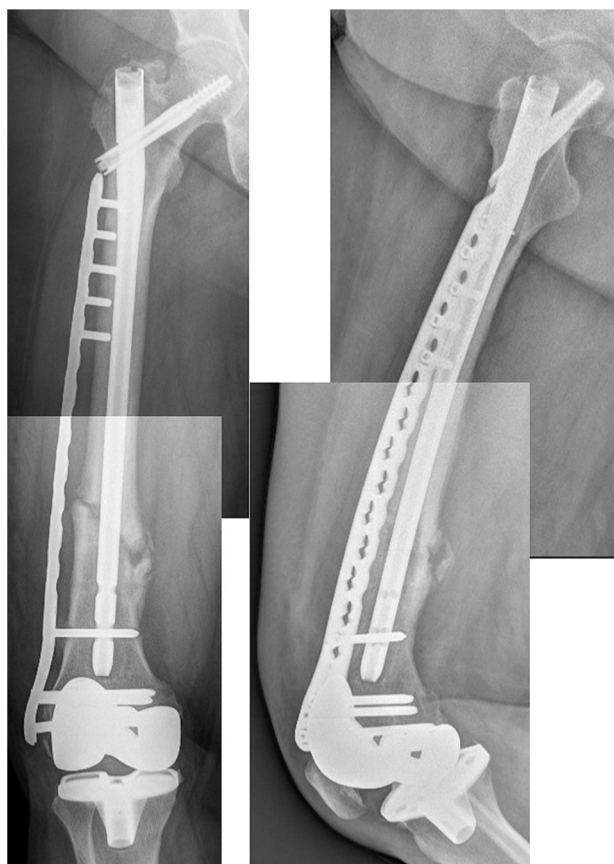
Radiographic anteroposterior (A) and lateral oblique (B) images from the first postoperative day after femoral fixation using a nail-plate.
